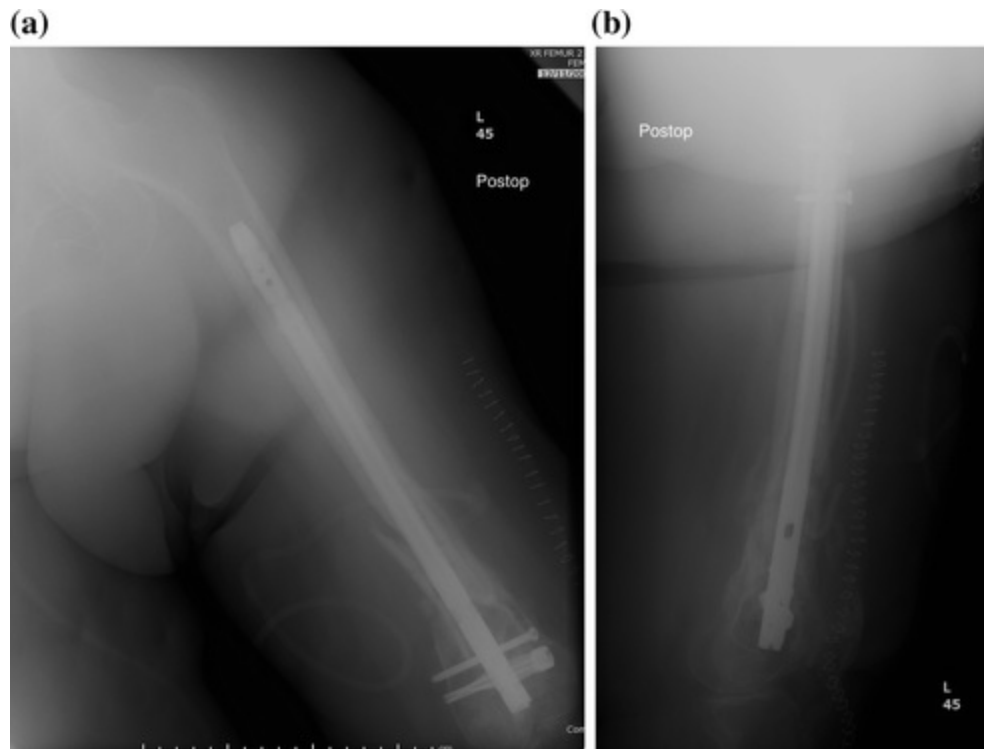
Immediate a anteroposterior and b lateral postoperative left femur radiographs showing stabilization of the nonunion with a retrograde nail and bone grafting
